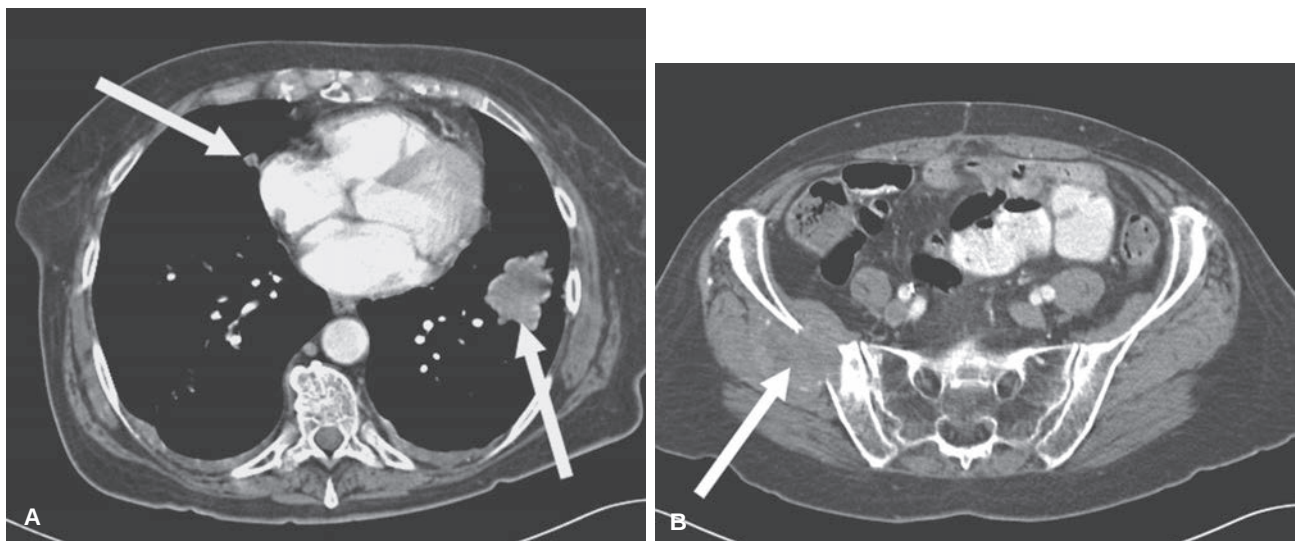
Recurrent endometrial carcinoma. Axial contrast-enhanced CT images through the lower chest (A) and pelvis (B) demonstrate lung nodules (white arrows in A) and a soft tissue mass with osseous destruction (white arrow in B), both proven to be recurrent endometrial cancer.
